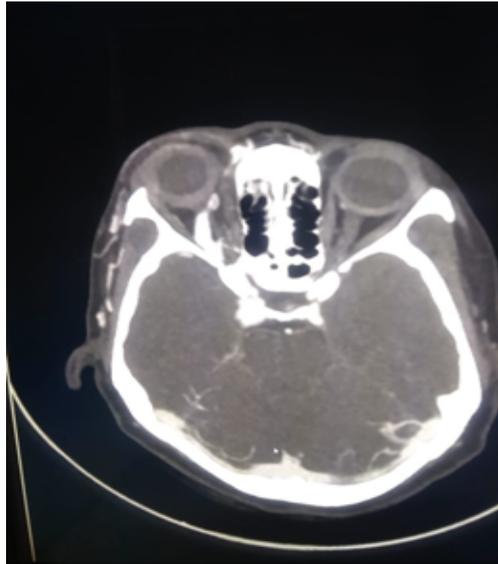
CT angiography report of patient with spontaneous CCF Filling of cavernous sinus noted during arterial phase with dilatation of right superior ophthalmic vein. Features suggestive of direct carotid cavernous fistula on right side
